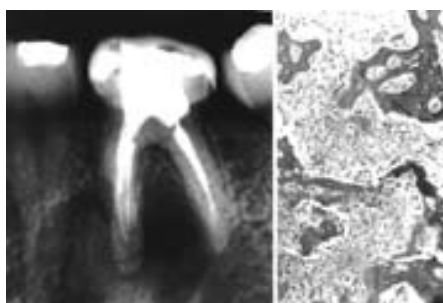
A persistent periapical radiolucency that was diagnosed as periapical cemento-osseous dysplasia after biopsy (right).
